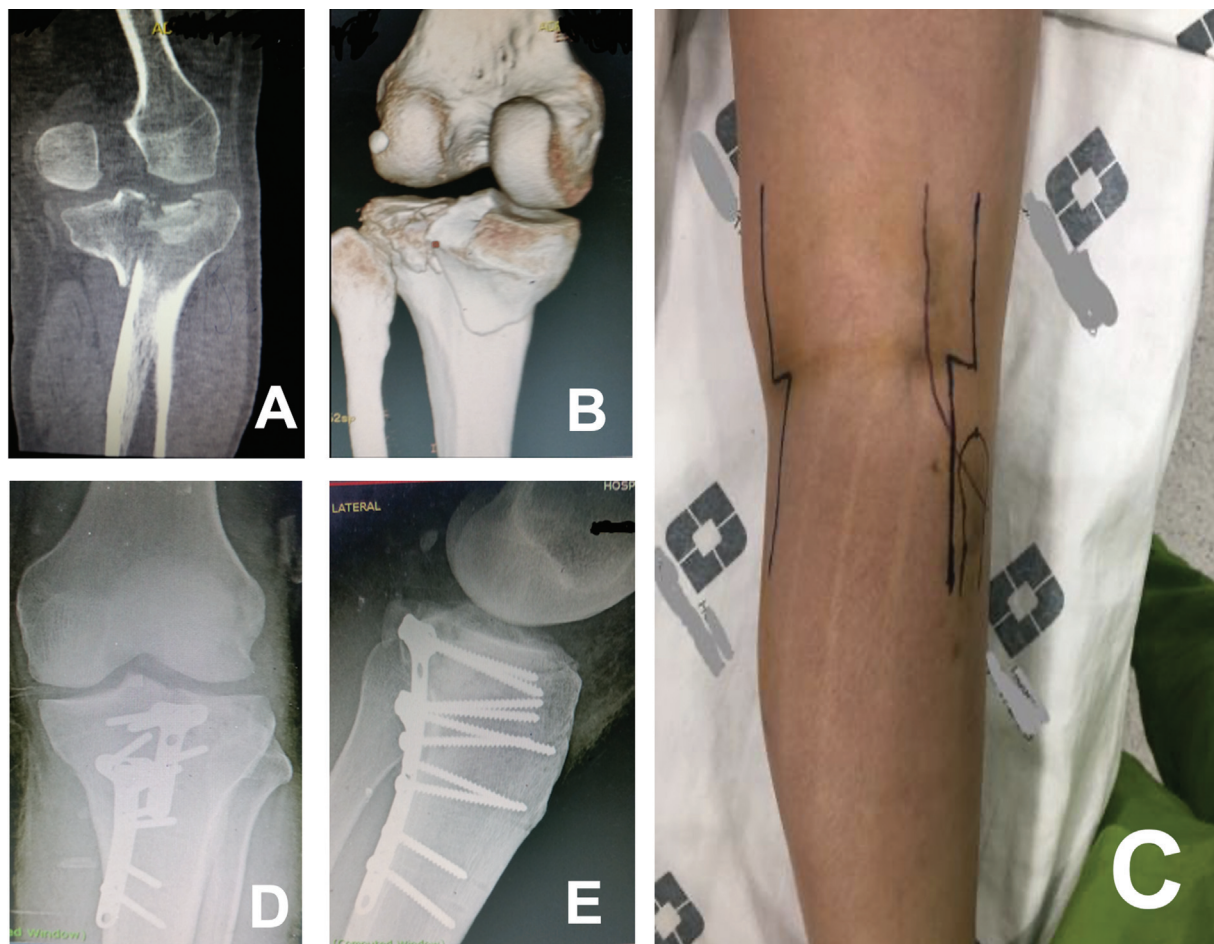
(A) Coronal section computed tomography, evidencing the lateral depression and medial shear of the joint surface. (B) 3D reconstruction of computed tomography showing a posteromedial shear. (C) Carlson's "S"-shaped lateral and medial operative incision. (D and E) Postoperative anteroposterior and lateral radiographs revealing fracture.
